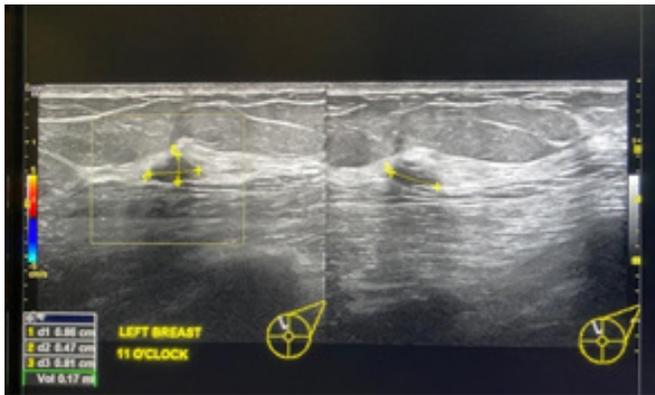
Ultrasound of the left breast showed a hypoechoic lesion in the 11-12 o'clock position with no internal vascularity
